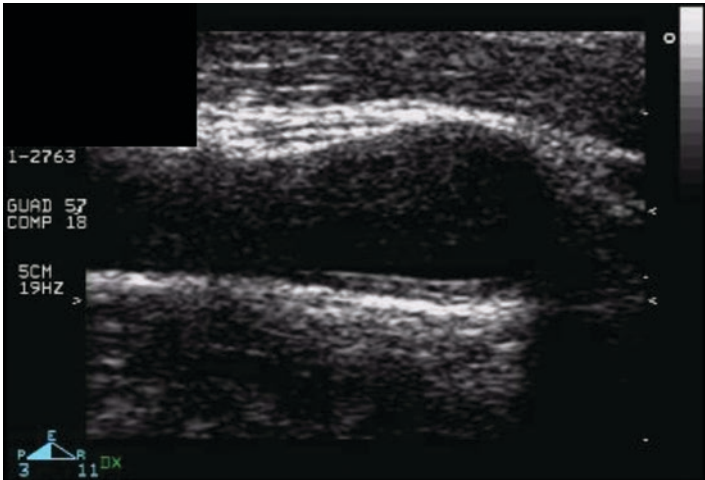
Carotid ultrasound at the first visit
